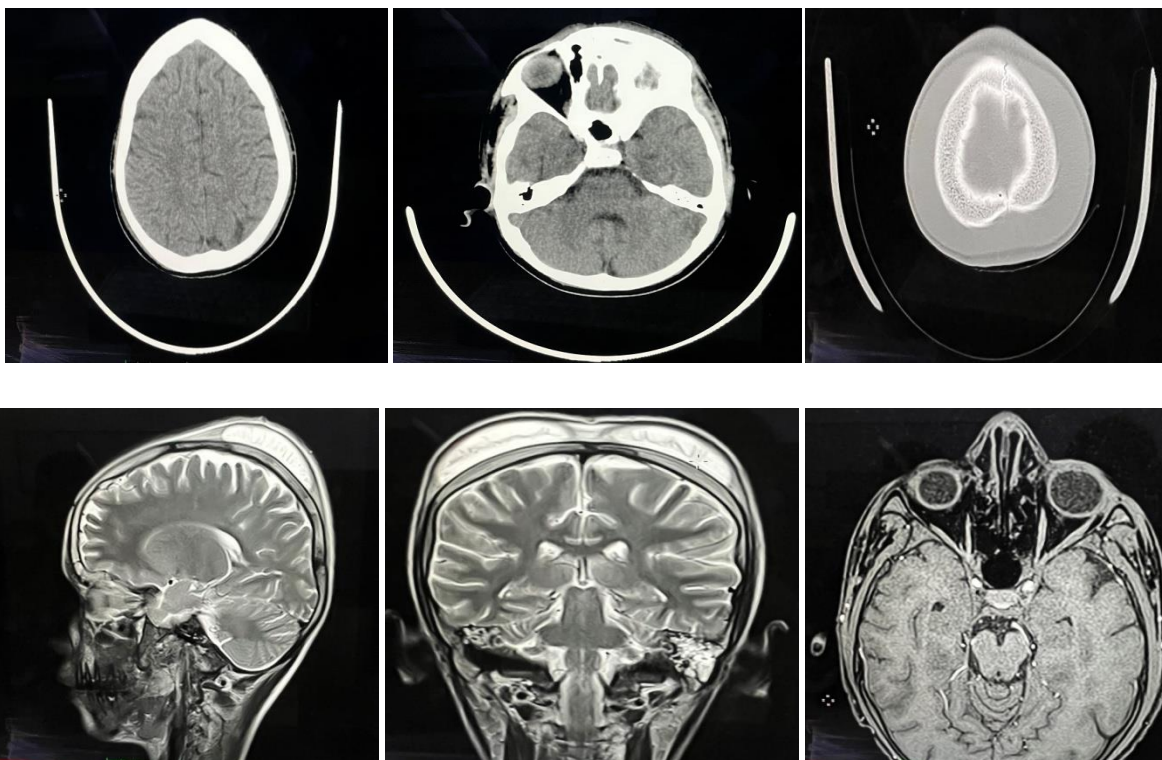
CT Scan Findings showing – a, b and c Medullary extension of bilateral zygomatic bone, d and e Showing Subgleal Hematoma, f – showing mastoiditis
